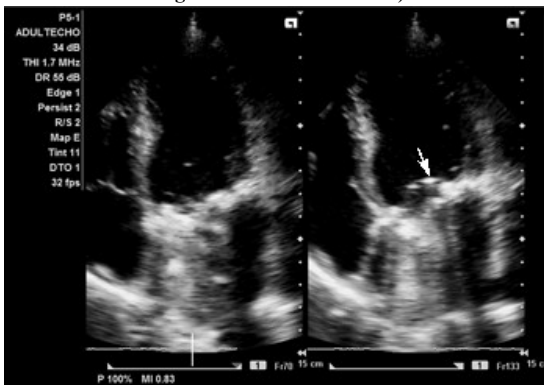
Echocardiography after Treatment (Arrow - Mechanical Valve, no fresh vegetation)
